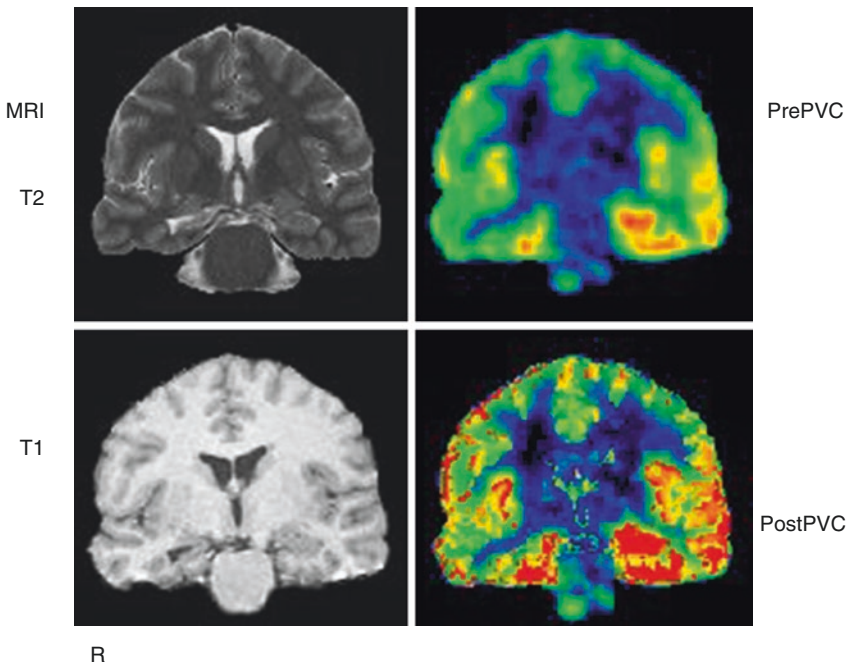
Partial volume correction of FDG-PET scan in a patient with mesial temporal sclerosis. After application of the gray matter mask, apparent glucose metabolism is increased throughout. However, the relative hypometabolism in the right temporal cortex is preserved
